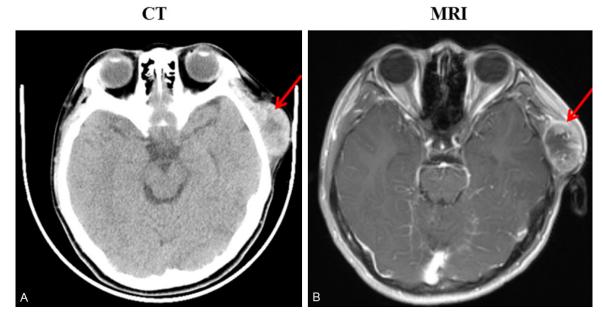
Radiological pictures of the lesion in case 1. A: Computed tomography (CT) scan showed some clumpshaped mixed density in the left temporal muscle (red arrow). B: Magnetic resonance imaging (MRI) revealed a large heterogeneous annular contrast-enhancing lesion in the same region. Hemorrhage and necrosis in lesions was also evident (red arrow).
